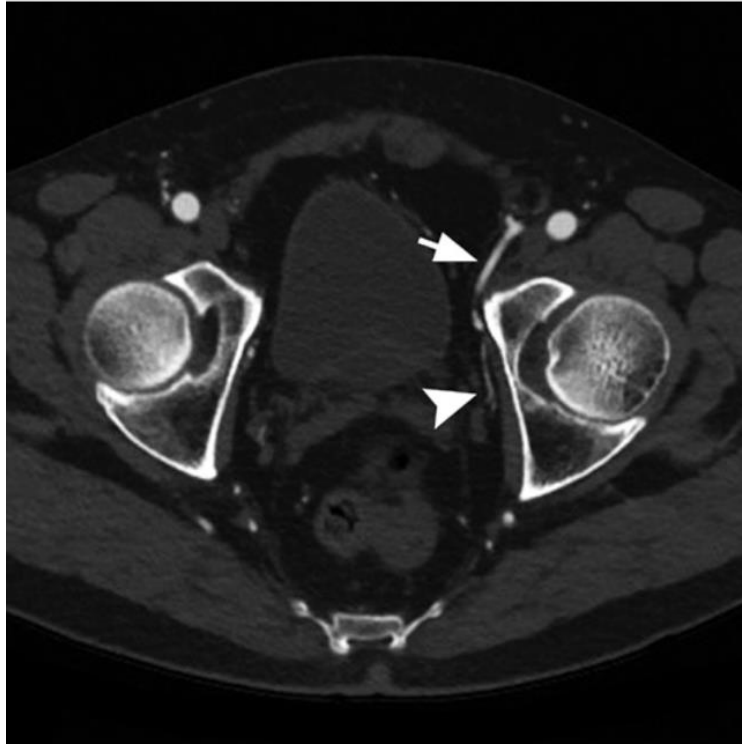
An auxiliary obturator artery gives rise to the prostate artery (PA). The PA (arrowhead) arises from an auxiliary obturator artery on a pre-procedural CT angiography (arrow) (33).
